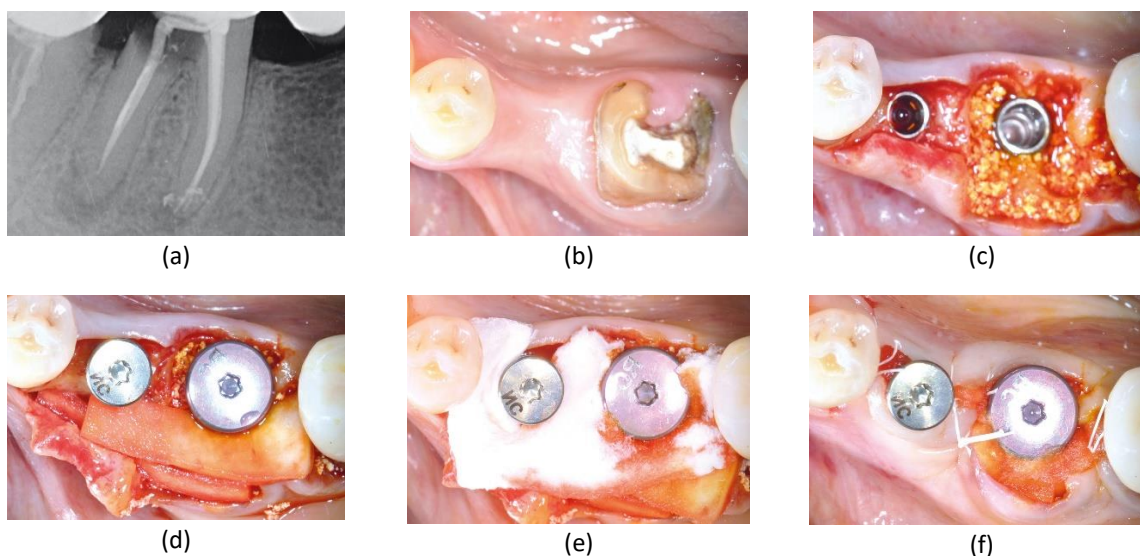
Patient 3: (a) X-ray control; (b) Initial clinical situation; (c) immediate implant placement with maxresorb®; (d) coverage and soft tissue management with mucoderm®; (e) coverage with collafleece®; (f) wound closure with fleece partially exposed.
